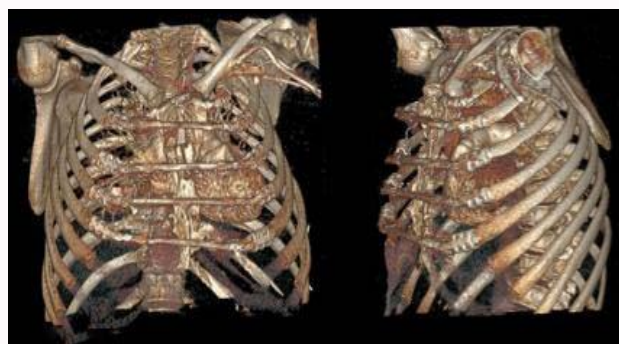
Post operative chest CT-scan 3D-reconstruction of position of the implanted STRATOS™ bars. A anterior view, B oblique anterior view.
